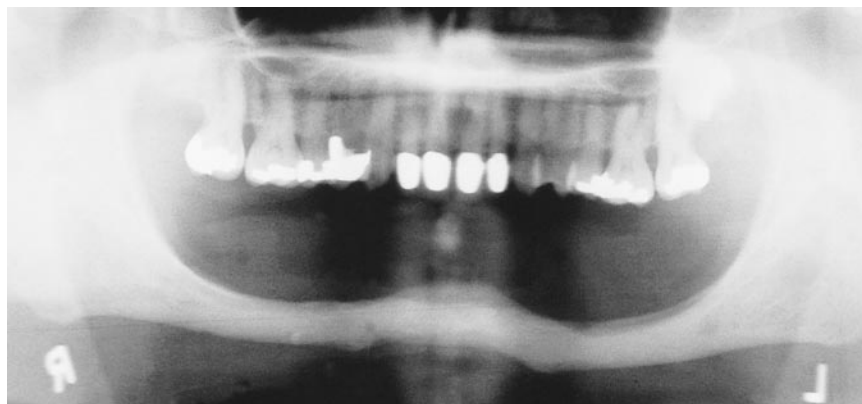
Preoperative panoramic radiograph clearly showing the patient's atrophic mandible and opposing full arch of natural dentition (dated April 11, 1985).
